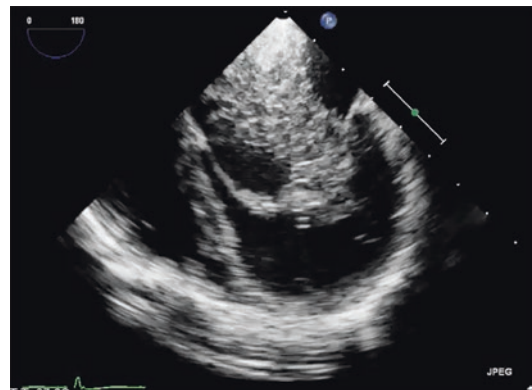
A 2D transesophageal echocardiography image of a giant left atrial myxoma popping into the left ventricle and obstructing the mitral valve flow during diastole
